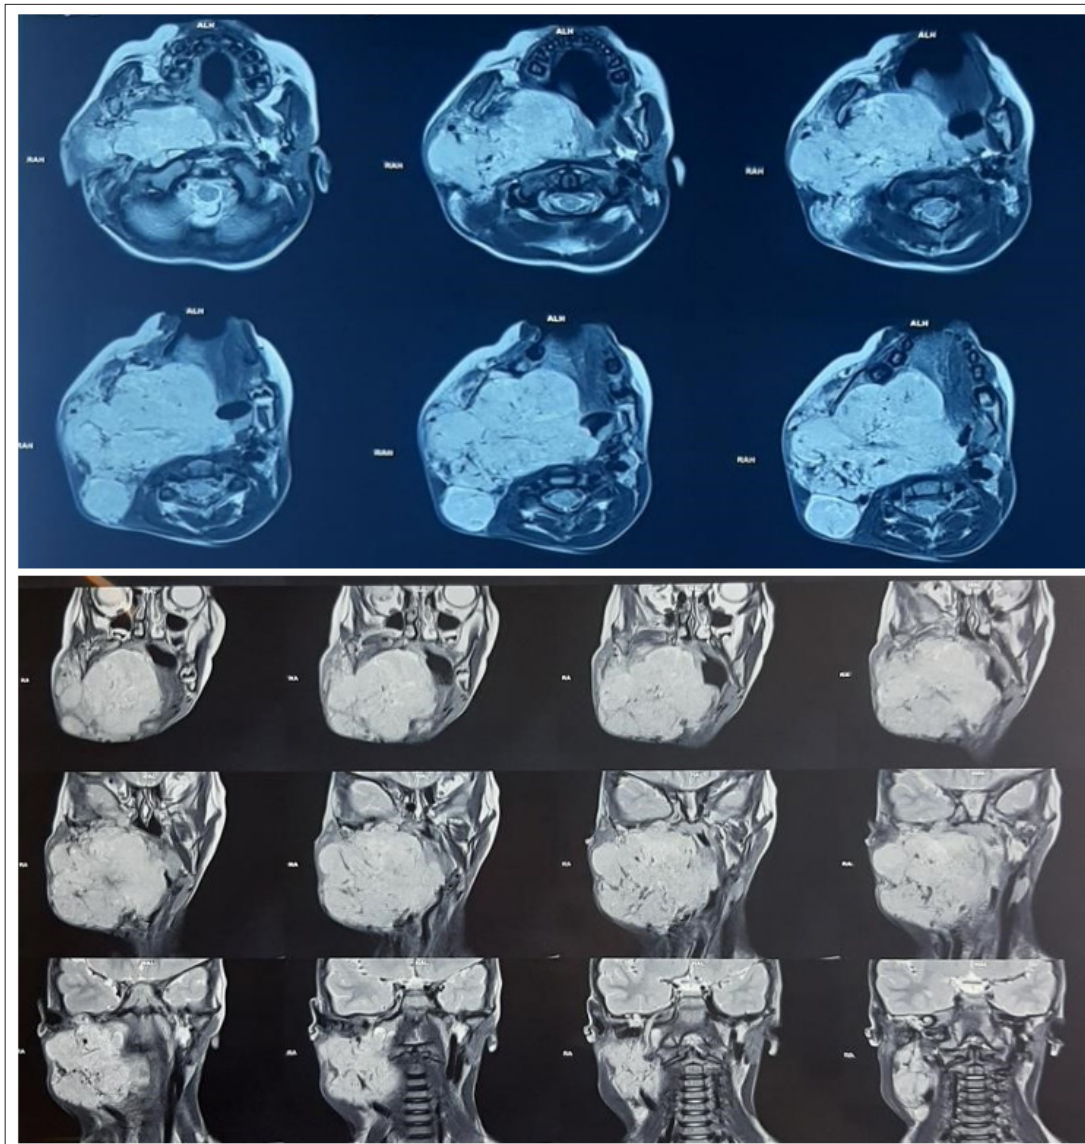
Magnetic resonance imaging (MRI) showing a large right lateral cervical mass centered on the parotid gland, roughly ovoid, well-defined, with lobulated contours, isointense on T1-weighted images and hyperintense on T2-weighted images
